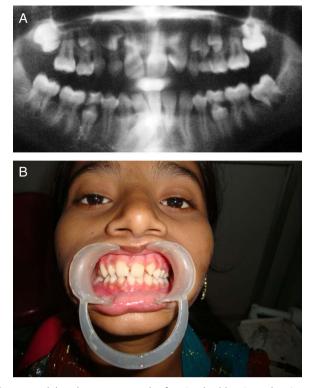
(A) Orthopantomograph of patient's elder sister showing congenitally missing 12, 22 and 32. (B) Photograph of patient's elder sister.
